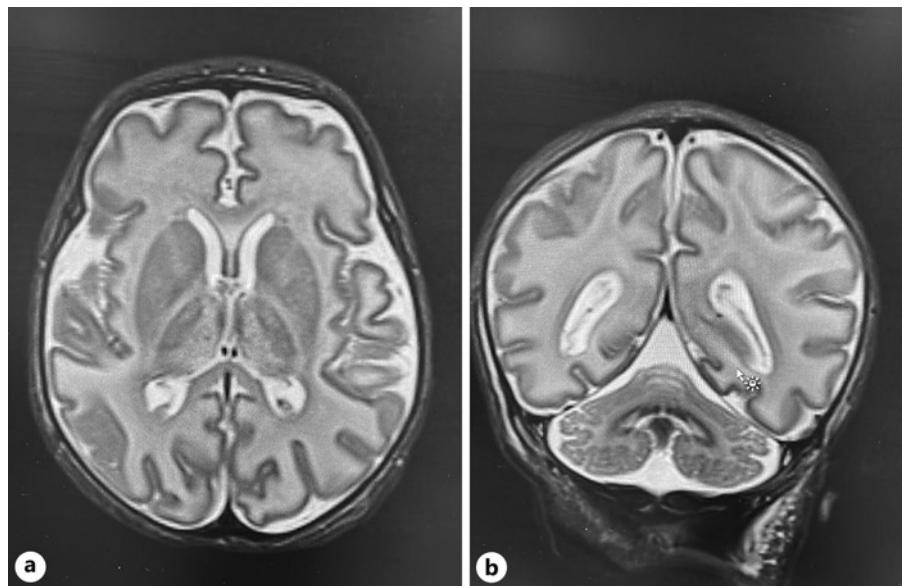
a, b MRI brain (day 7) showing abnormalities in periventricular white matter, internal capsule, and brain stem.
